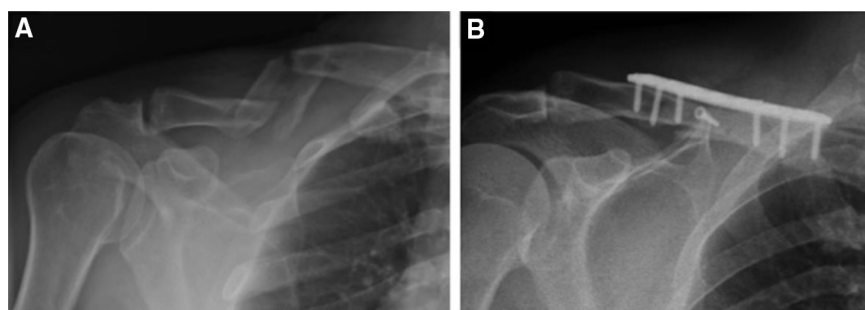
A 45° up-tilted clavicle radiograph shows (A) a Robinson type 2B2 fracture (displaced, comminuted, and segmental) and (B) bony union and that the precontoured plate fits the anatomic shape of the biological clavicle.
